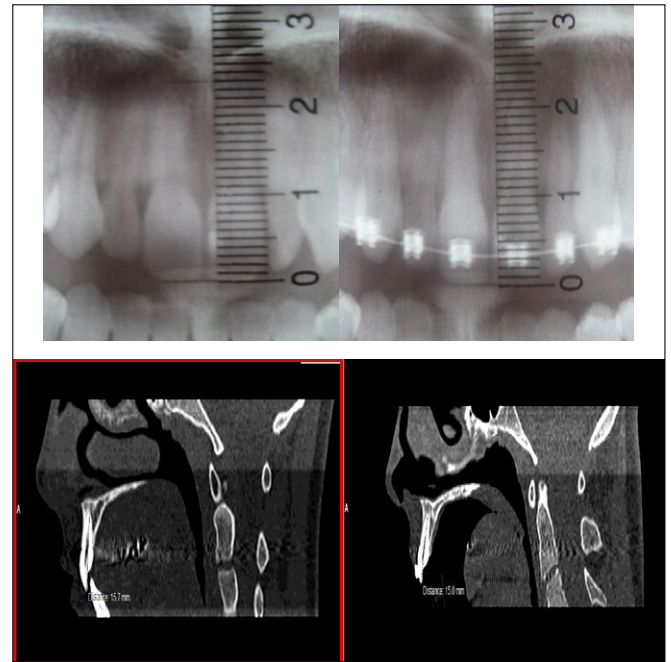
OPT: No signs of apical resorption. CT: Evident apical resorption.
